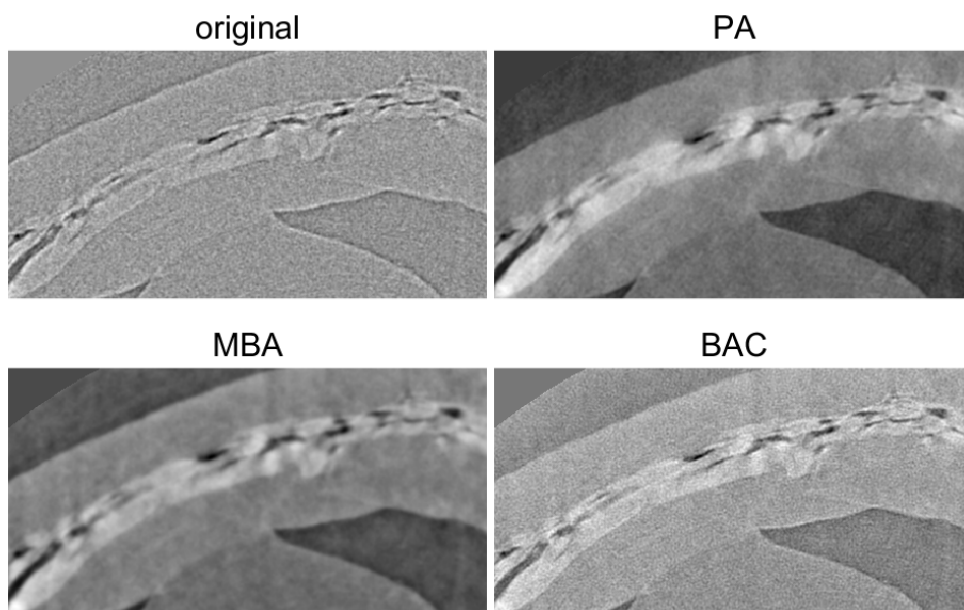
Details of CT slices of PEDT with different phase retrieval algorithms (Paganin algorithm – PA, Modified Bronnikov algorithm – MBA, Bronnikov aided correction – BAC).
